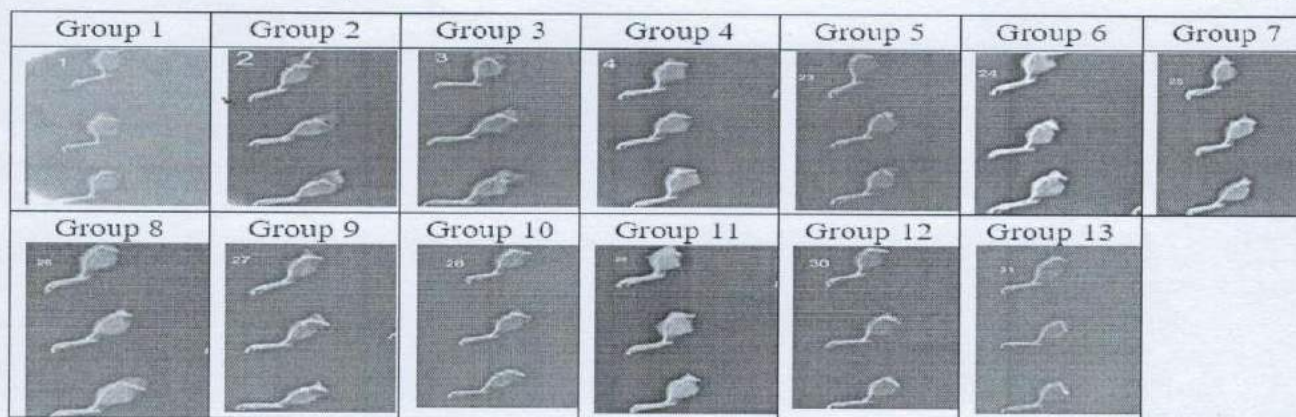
Effect of *Asparagus officinalis* extracts on arthritic joints in X-ray.
